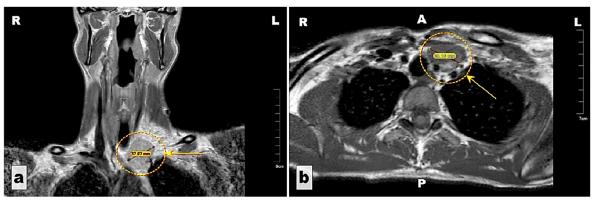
Left anterior mediastinal mass (yellow circles and arrows): (a) MRI – coronal view; (b) MRI – axial view. A: Anterior; L: Left side; MRI: Magnetic resonance imaging; P: Posterior; R: Right side.
